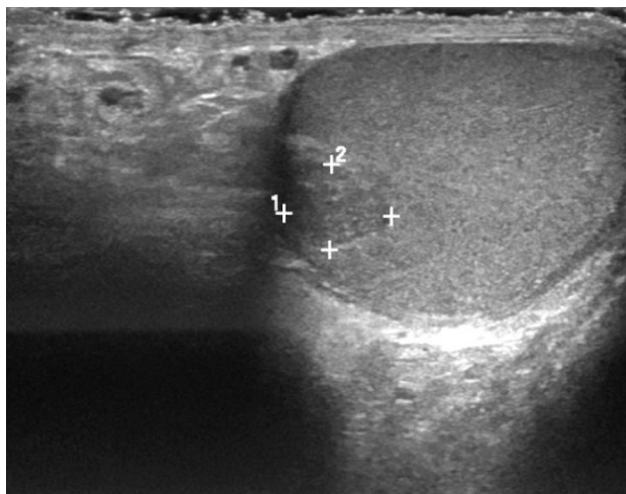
Ultrasound of the right scrotum demonstrating a $0.9 \times 0.7 \times 0.8$ -cm marginated hypoechoic area (white crosses) in the upper pole of the right testicle.
